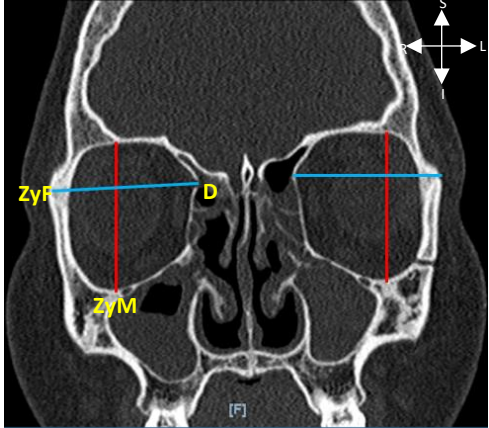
CT scan in the orbital region displaying the orbital height (red) and orbital width (blue) (Coronal view)
